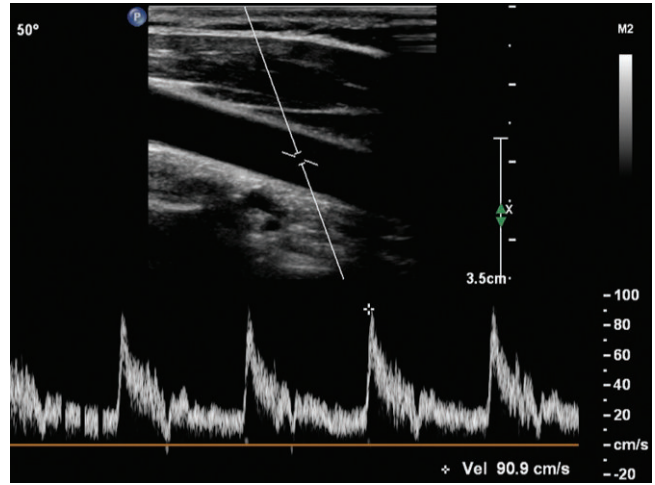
Spectral Doppler angle correction is correct. The angle is set parallel to the vessel walls. The Doppler angle is 50 degrees. A Doppler angle at or less than 60 degrees is acceptable. Note the difference in peak systolic velocity between Figures S21-1 and S21-2; 69 and 90 cm/s is a significant difference.
